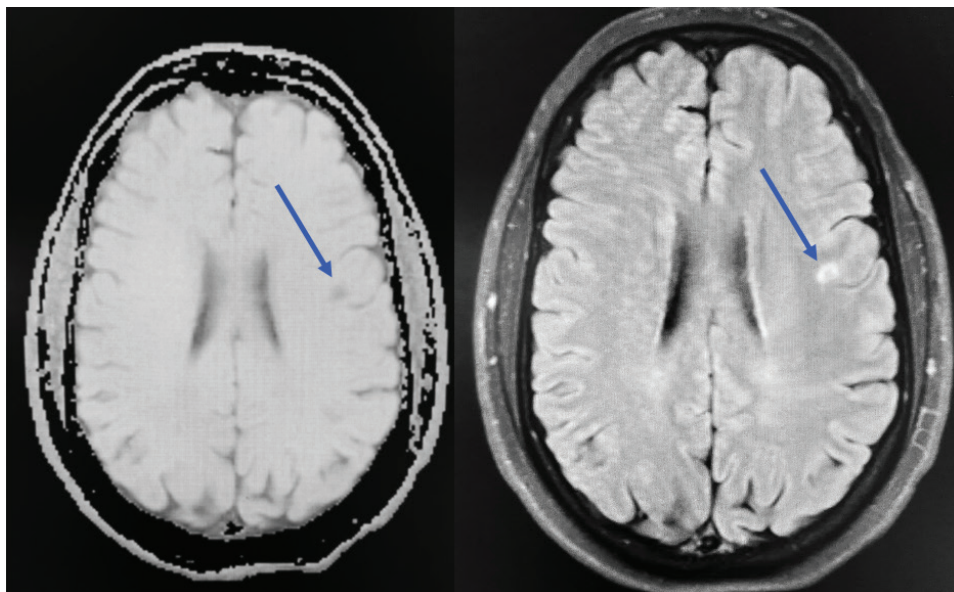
Magnetic Resonance Imaging - Axial images of the lesion in the frontoparietal region with T1 (Left) and T2 Flair (right) with the use of gadolinium contrast.
